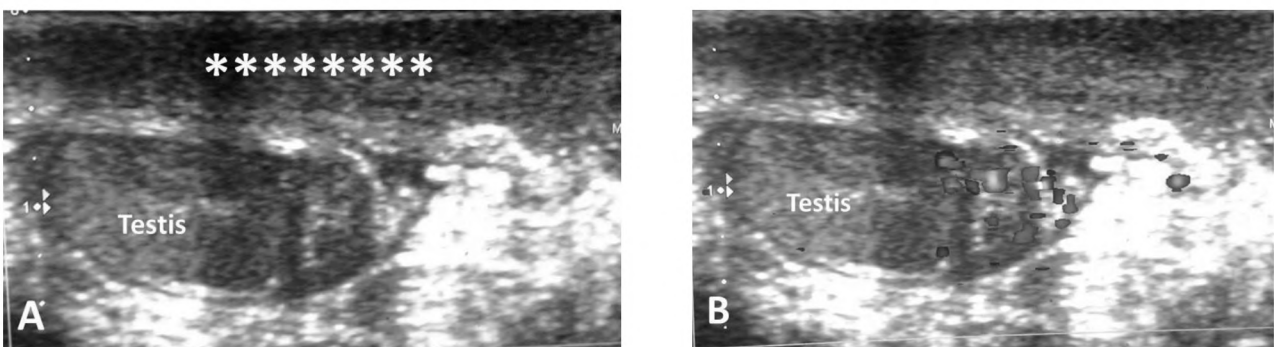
Scrotal parietal layers diffuse hematoma. (A&B) Sonography and color Doppler images showing the diffuse parietal hematoma (\*\*\*\*\*).
